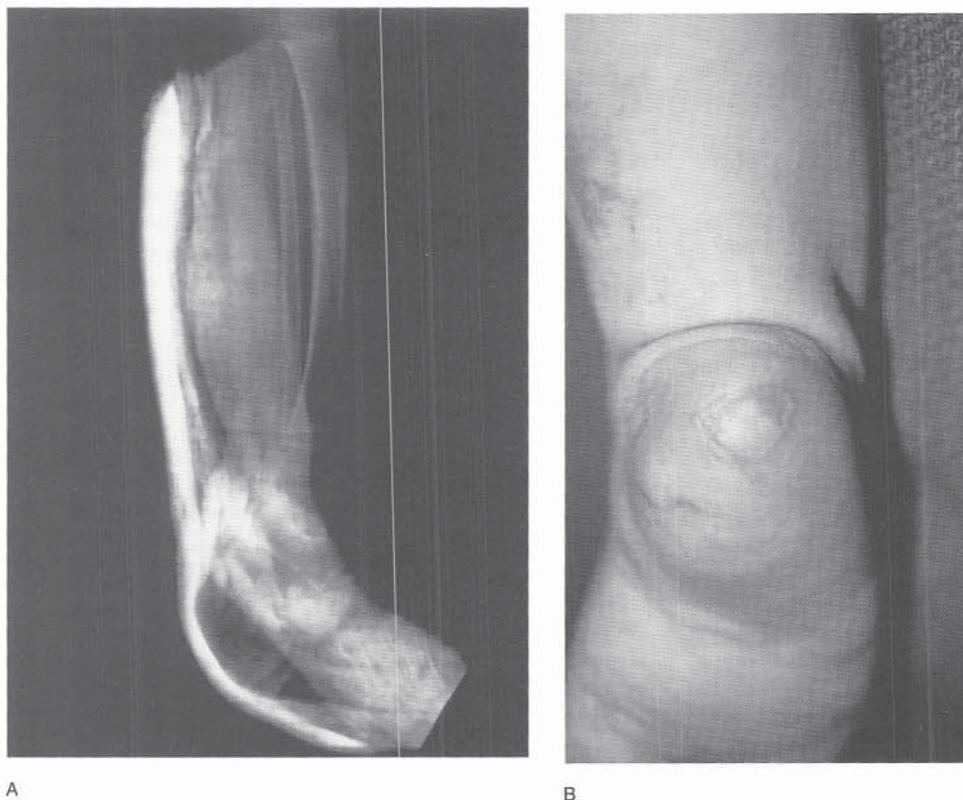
Pressure sores following distal migration of a splint. A, Lateral radiograph of a poorly molded posterior splint. The splint has slid distally and is impinging on the heel. B, When the splint is removed there is blistering on the heel.
